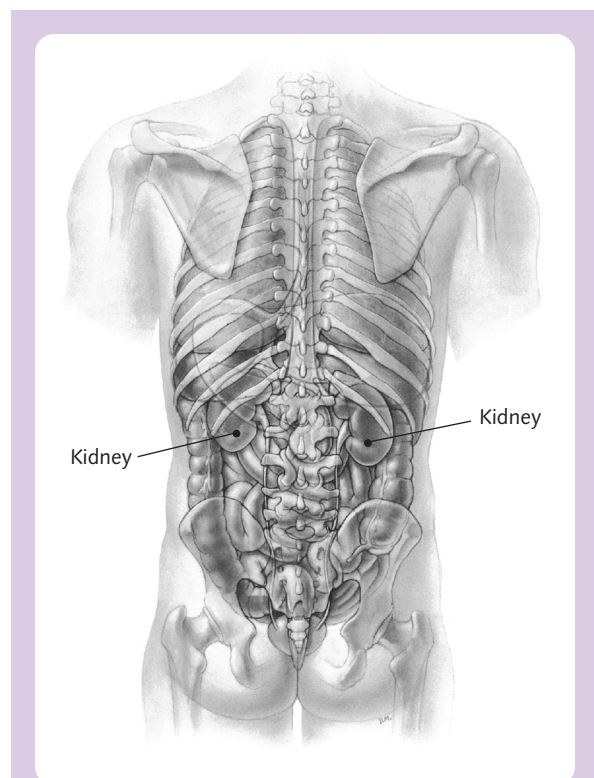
Renal anatomy. The kidneys are often positioned relatively high within the abdomen. Most MRI protocols include a combination of axial and coronal imaging. *Courtesy of LifeArt.*
